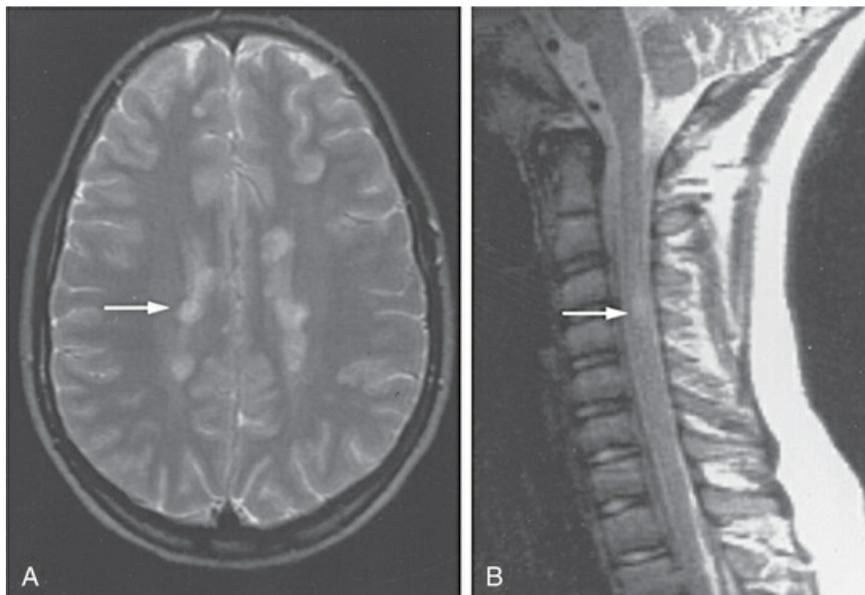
Multiple sclerosis. A, MRI scan of brain demonstrates multiple lesions located in the white matter characteristic of multiple sclerosis (*arrow*). B, MRI scan of spine indicates a demyelinating plaque of multiple sclerosis in the midcervical region (*arrow*). (From Kliegman RM, et al, editors: *Nelson textbook of pediatrics*, ed 18, Philadelphia, 2007, Saunders.)
